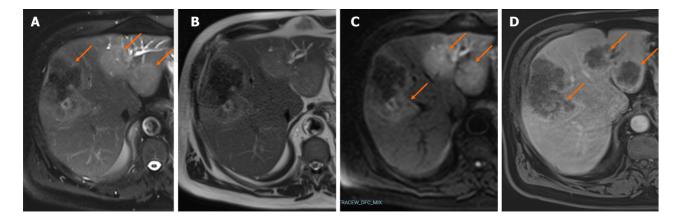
A case of Echinococcus alveolaris in the liver. In Gd-EOB-magnetic resonance imaging of a 69-year-old male patient. A and B: On with and without fat-suppressed T2-weighted images the lesions appear slightly hyperintense and hypointense areas in the central part of the largest lesion (orange arrows); C: Diffusion-weighted imaging reveals restriction of diffusion of the lesions (orange arrows); D: The lesions show peripheral rim-like enhancement on the hepatobiliary phase (orange arrows).
